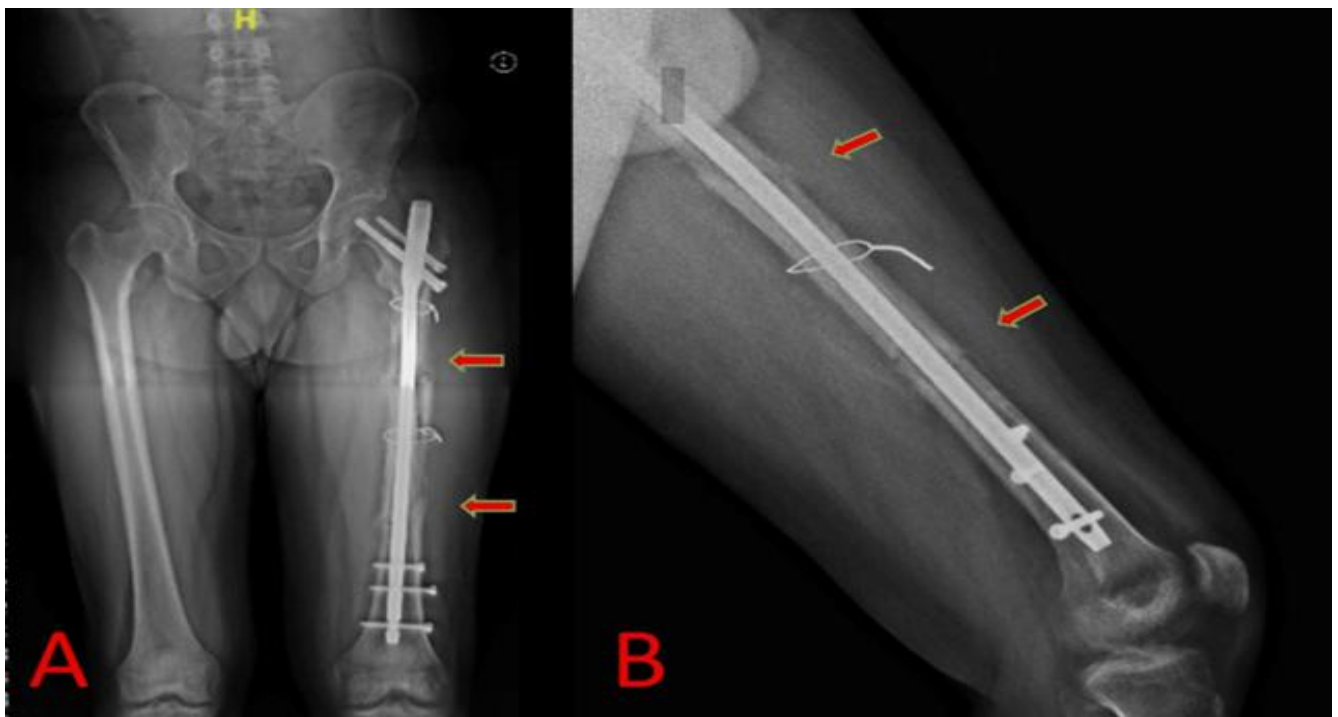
(A and B): Anteroposterior and lateral radiographs of the left femur at two-year follow-up in case 1 showing complete union of the subtrochanteric and segmental shaft fractures with maintained alignment and implant integrity. (A) Anteroposterior radiograph of left femur showing complete union of the subtrochanteric and segmental shaft fractures. (B) Lateral radiograph of the left femur showing complete union of the subtrochanteric and segmental shaft fractures.
